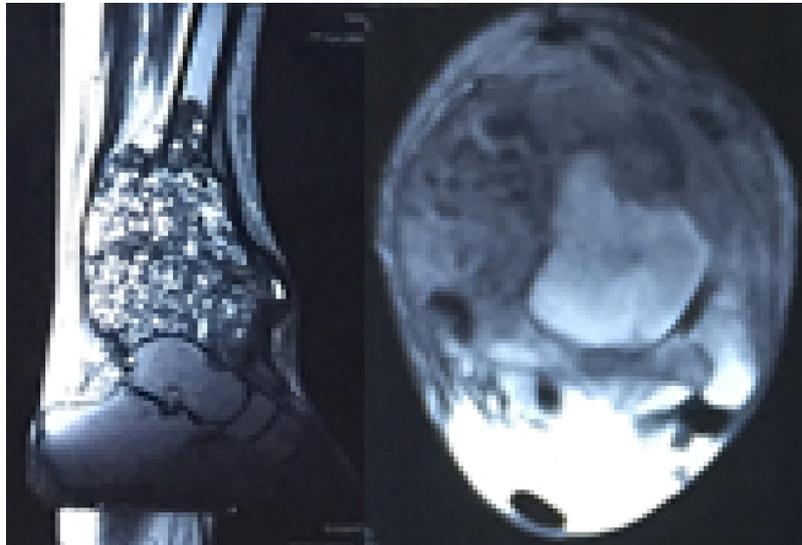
MRI showing no perilesional edema and no soft tissue extension. The mass was diagnosed radiologically as primary bone tumor of giant cell type.
